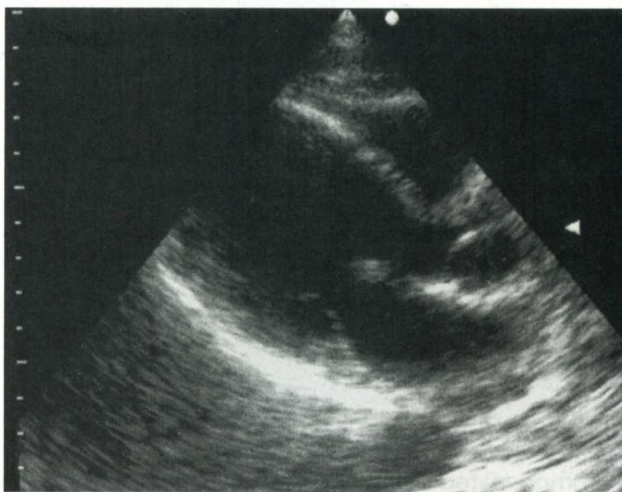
Dilated left ventricle in parasternal long-axis view.
